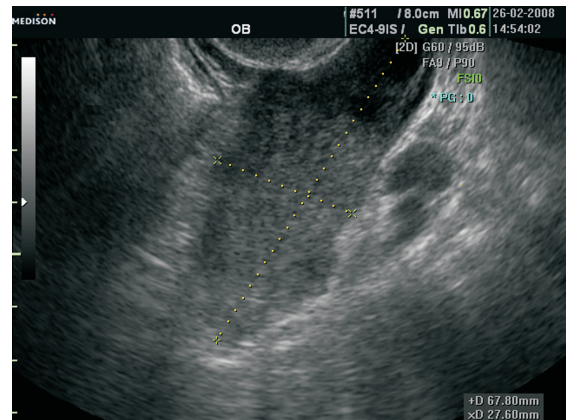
Transvaginal ultrasonography showing a solid-cystic tumor in the left adnexal region with the solid part measuring 68x28 mm.
